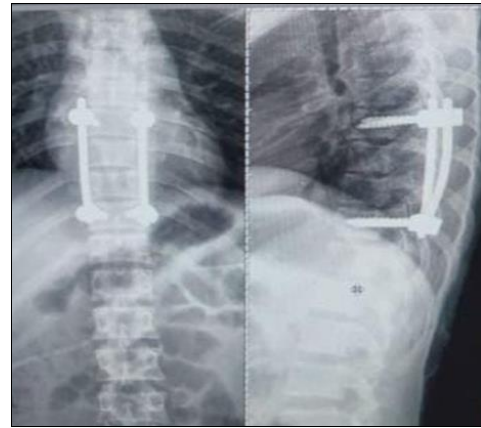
post op x-ray (posterior fixation using pedicle screws & connecting rod)
